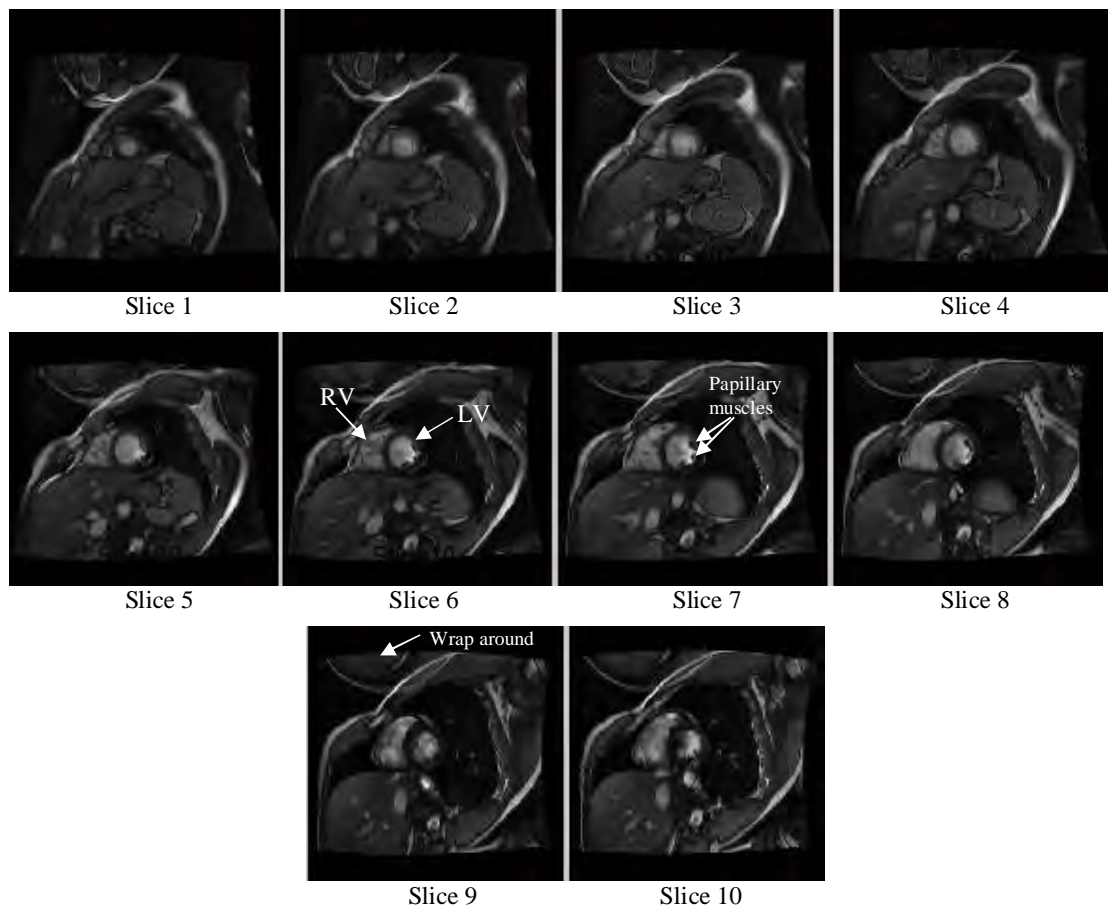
Examples of Cardiac MRI in Short Axis View per slice.
